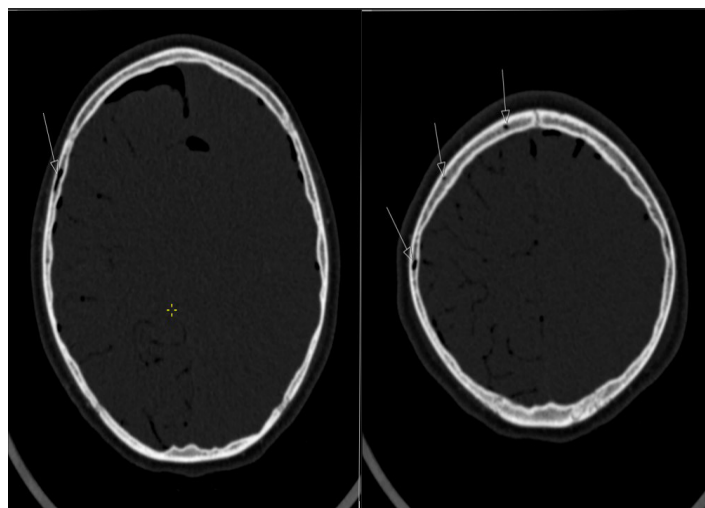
Bone window images of enhanced cranial CT. Air densities in the right parietal bone emissary veins (white arrow) and cerebral sulcal spaces prominent at right cerebral hemisphere.
